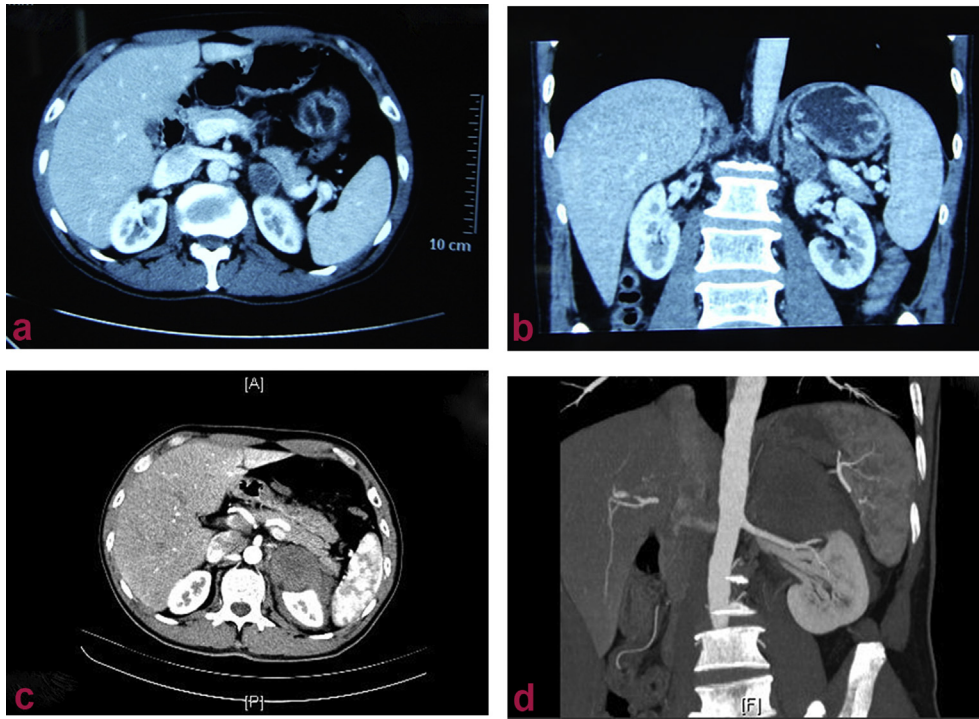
CT scan of the abdomen was noted. (a), (b) CT scan indicated left adrenal mass by physical examination. (c), (d) CT scan demonstrated that space-occupying lesions with effusion around the left adrenal, including the possibility of hematoma after acute left flank abdominal pain.
